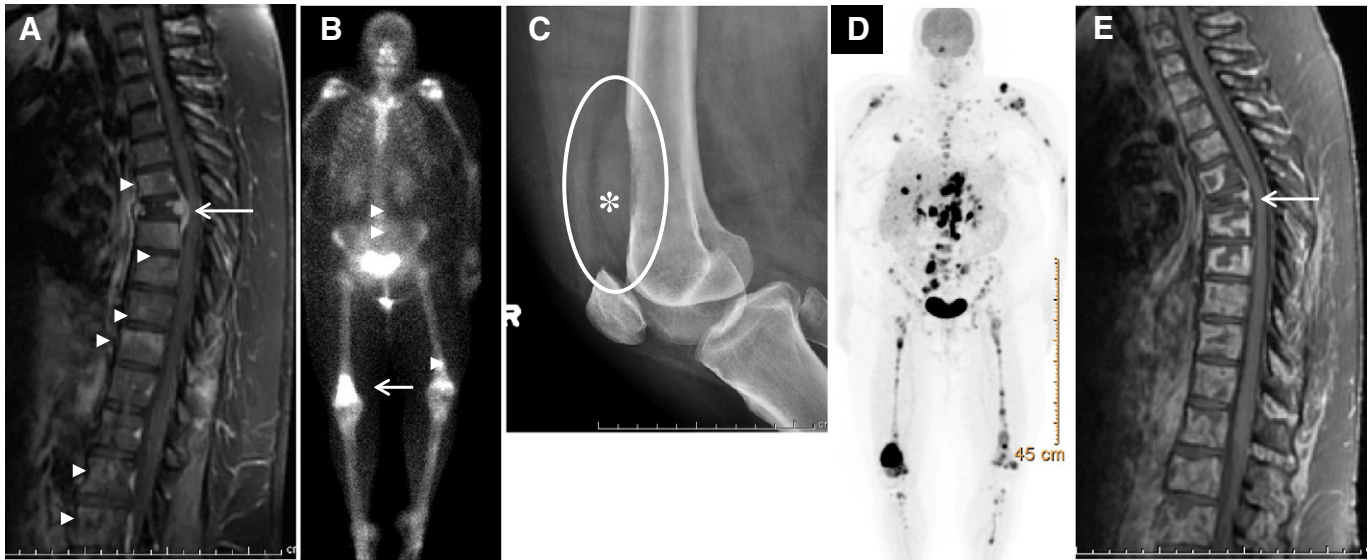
MRI of the thoracic spine (A) shows multilevel vertebral body lesions (arrowheads), and compression fracture of the T6 vertebral body associated with epidural extension (arrow); ^{99m}Tc Bone Scan (B) demonstrates extensive spine and extremity bone lesions (arrowheads), including right femur (arrow); right knee X-ray (C) and MRI (not shown) were obtained to exclude a pathologic fracture. An anterior cortex, lytic lesion with associated soft tissue component (*) was seen. No fracture was demonstrated; FDG-PET/CT (D) revealed multiple lymph nodes, liver and renal metastases and confirmed osteolytic metastases throughout the spine and extremities. Post therapy MRI (E) demonstrates decreased epidural metastasis (arrow) at site of focused radiation; however the remainder of the spine is now diffusely involved.
